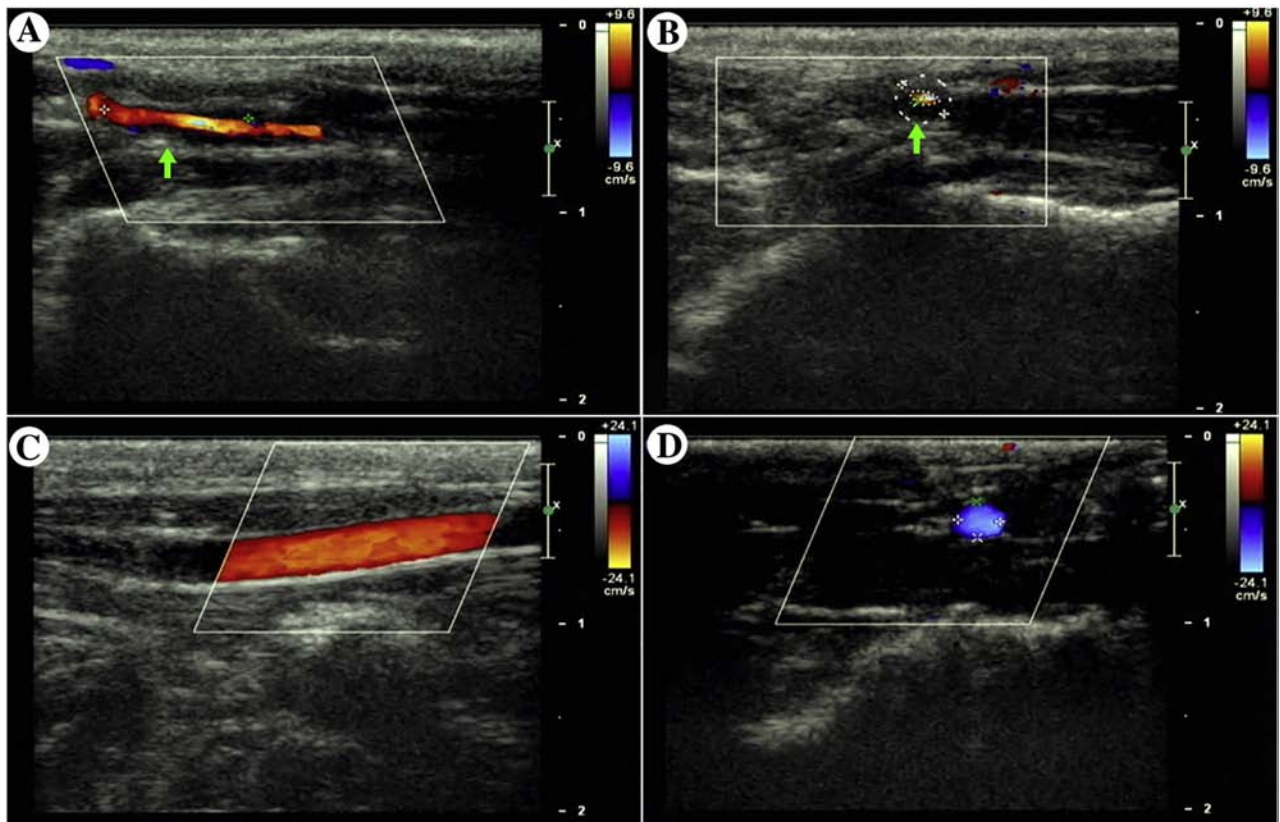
Carotid ultrasonography. (A) Longitudinal image of atherosclerotic carotid artery showed arterial wall thickening and plaque formation (arrow). (B) Cross-section image of atherosclerotic carotid artery showed arterial wall thickening and lumen stenosis (arrow). (C) Longitudinal image of normal carotid artery showed arterial wall smoothness. (D) Cross-section image of normal carotid artery showed regular vessel lumen.
